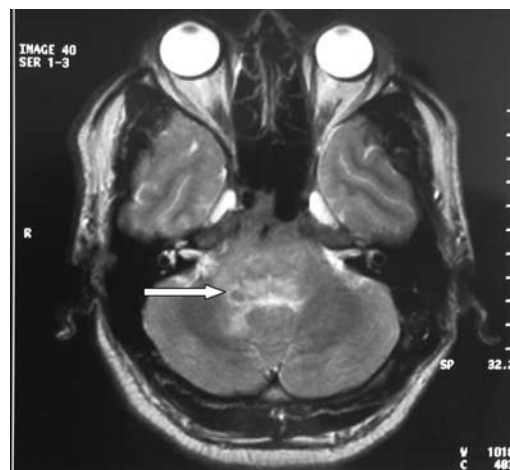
An magnetic resonance imaging demonstrated an iso/hypointense, diffuse brainstem lesion. The arrow indicates the diffuse brain stem glioma.
